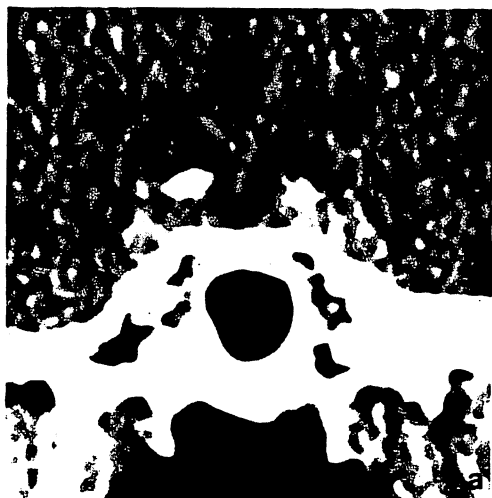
A 54-year-old male with nonfunctioning pituitary adenoma (case 7). a Enhanced CT demonstrates the high density of internal carotid arteries (arrows). Bulging of the left cavernous sinus may be noted (arrowheads). b T1-weighted SE image. Left carotid artery (straight arrow) is displaced infero-laterally and engulfed by the tumor. The tumor extends to the lateral wall of the cavernous sinus (arrowheads). Relatively low intensity of venous flow (curved arrow) is noted on the right side and it is not observed on the left side due to the invasion of the tumor
